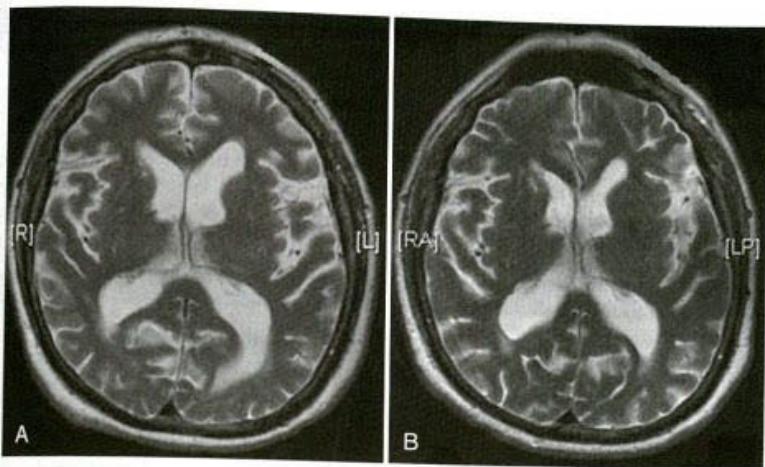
A, Example of a preoperative scan in a patient with normal-pressure hydrocephalus (NPH)—T2-weighted magnetic resonance imaging. B, Example of a postoperative scan in a patient with NPH and a good outcome (ventricular catheter not well demonstrated at this level).
